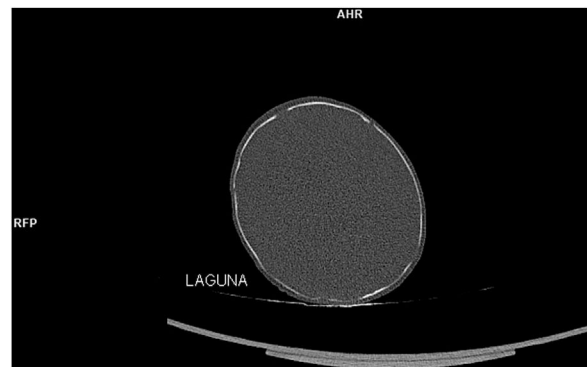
Computed tomography scan axial view through the parenchymal window, showing the lacunae in the skull cap, most pronounced in the right parietal bone.
